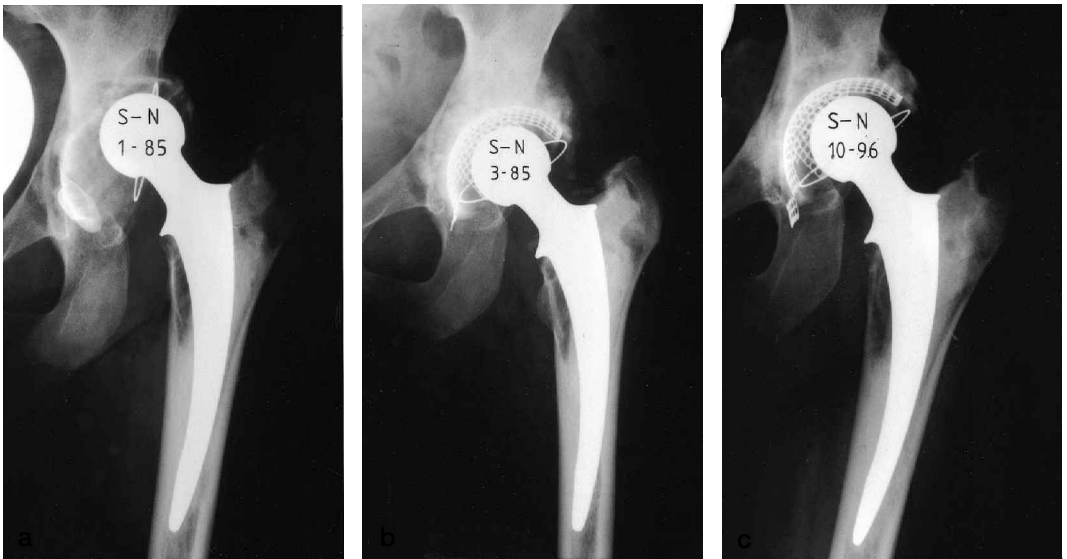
Case 27. Reconstruction after aseptic cup loosening in a patient with rheumatoid arthritis. Age at reconstruction 30 years. Preoperative (a), postoperative (b) and 11-year (c) follow-up views. No radiographic signs of aseptic loosening. However, the cup was changed 12 year postoperatively in a femoral revision for aseptic loosening due to matching problems and some polyethylene wear.
